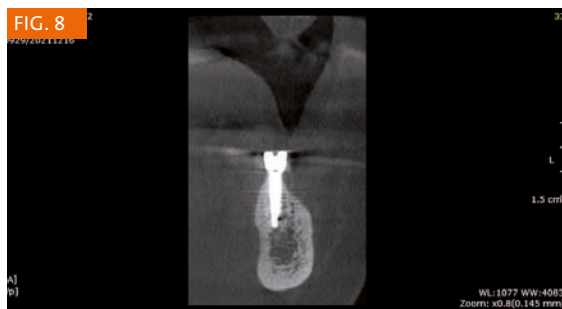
CBCT after 6 months (coronal section in position 3.7).
